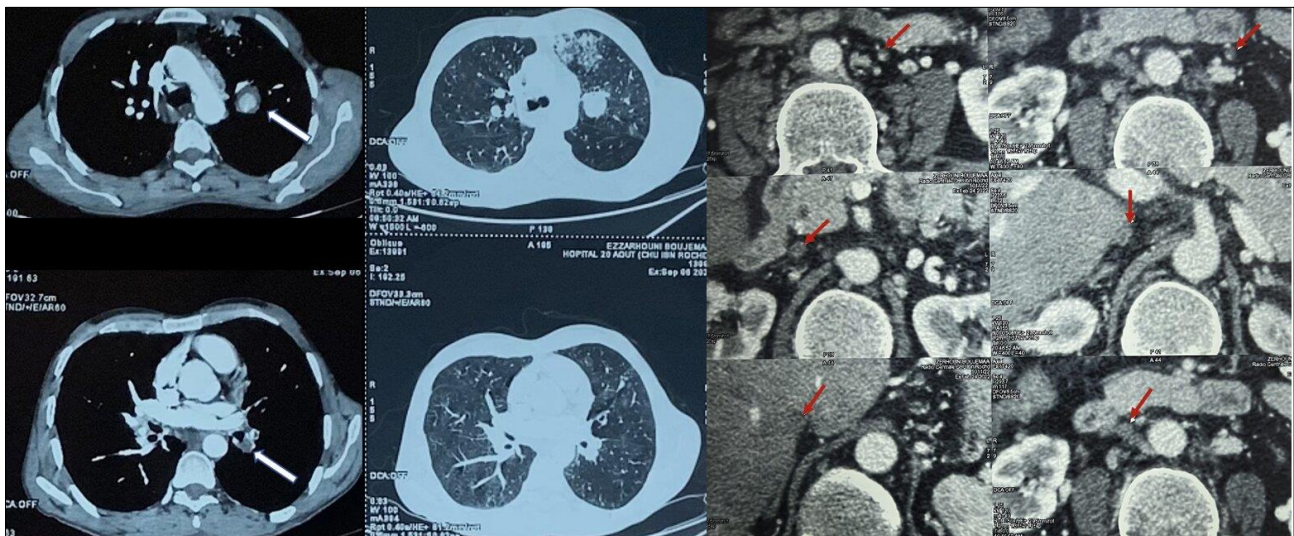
Thoraco-abdominal CTA showing a thrombosed aneurysm of the left pulmonary artery branch
